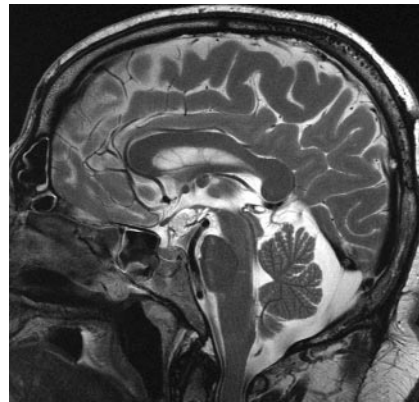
A sagittal T2-weighted image (FOV, 1024 × 384 mm; section thickness, 3-mm) obtained in a patient with a suprasellar dermoid. Note the z-axis uniformity of signal intensity from convexity through the foramen magnum on this image obtained with an eight-channel head coil
